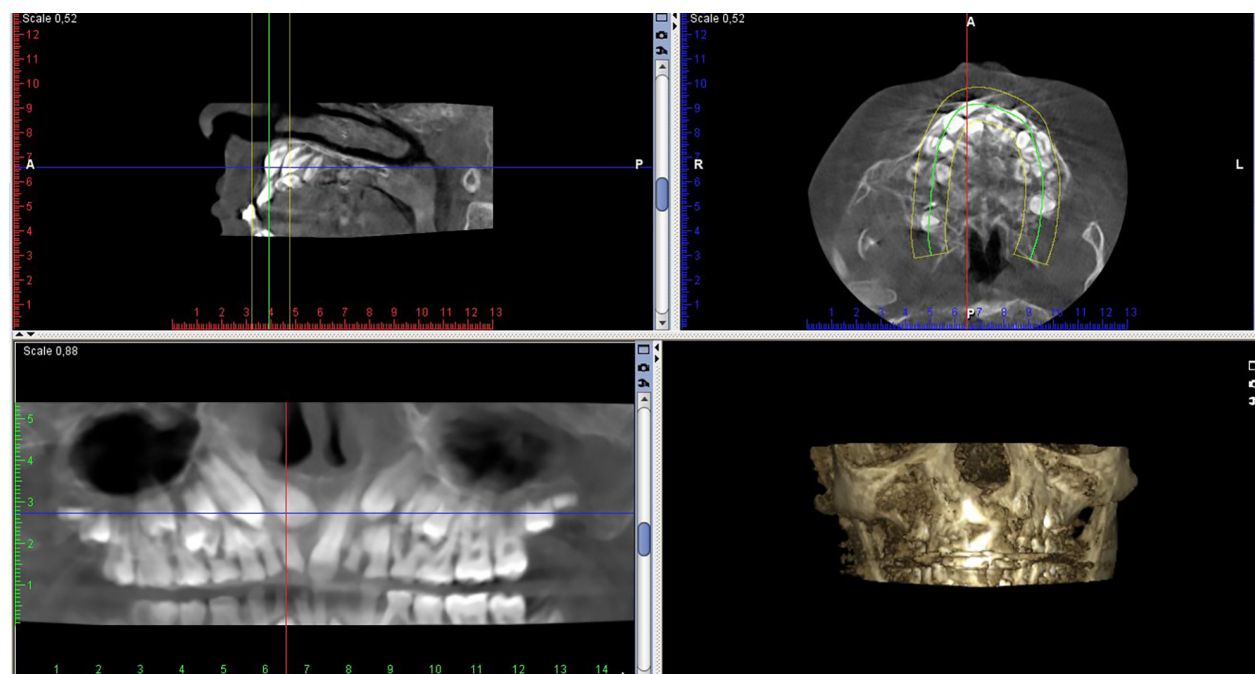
CBCT on patient A.K. in 2022.
